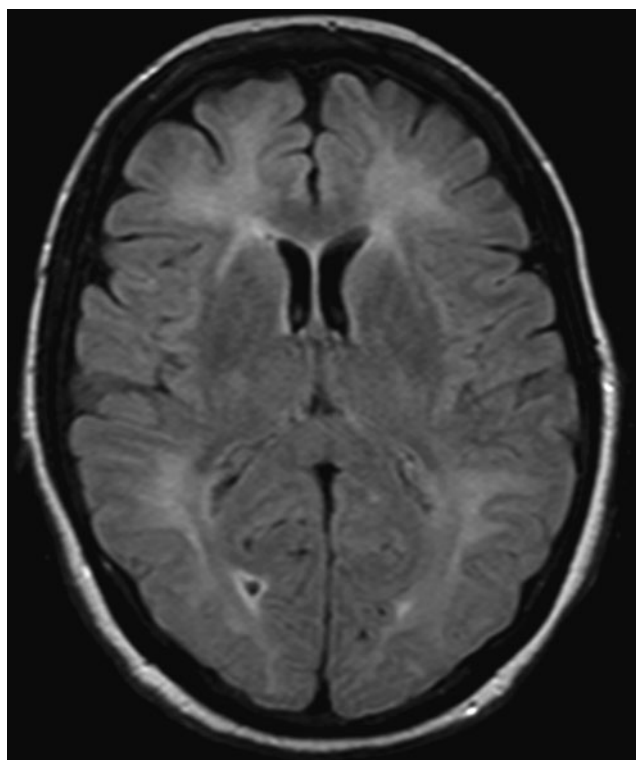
Magnetic resonance imaging fluid attenuation recovery demonstrating white matter hyperintensities involving the subcortical U fibers.
